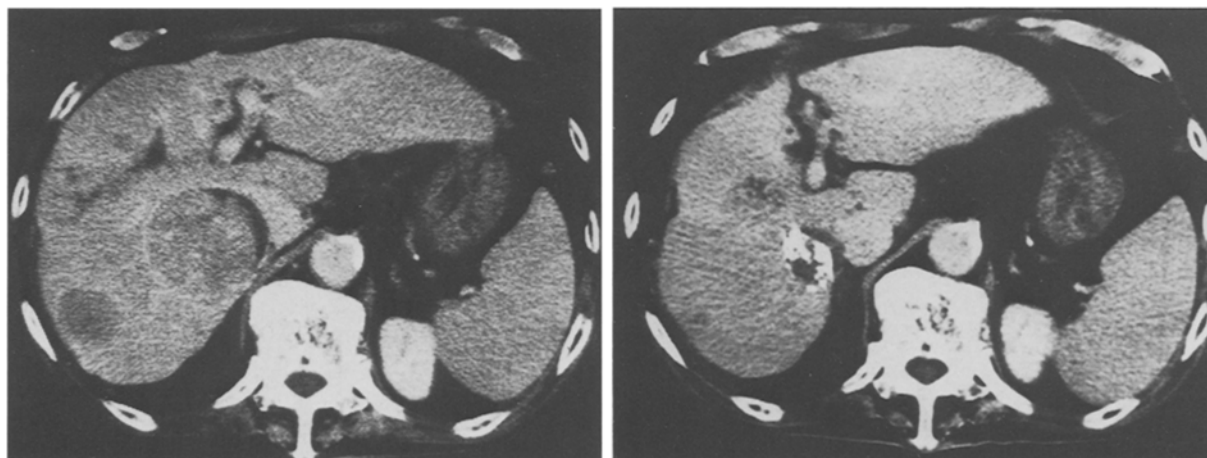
HCC in a 77-year-old man (a) A CT scan reveals multiple tumors with a well-enhanced rim in the liver (b) At 2 months after the onset of therapy, a CT scan shows marked contraction of each tumor and dense accumulation of Lipiodol
